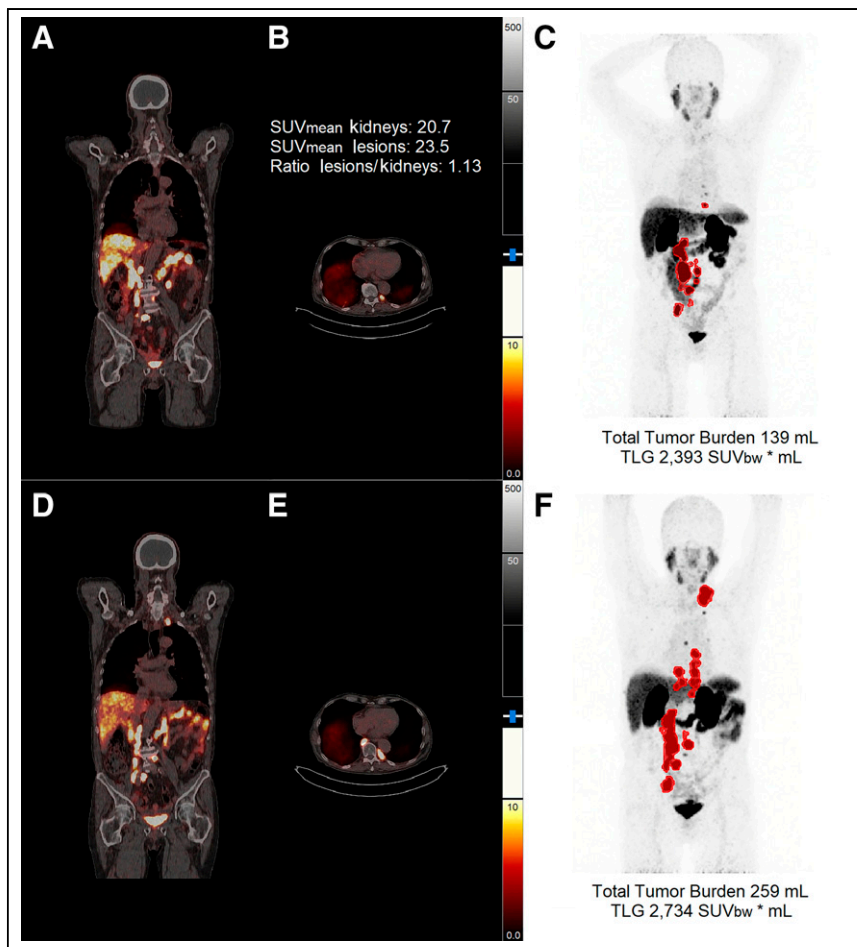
Results from one nonresponder. (A–C) PET/CT imaging before first therapy cycle. (D–F) PET/CT imaging after 2 therapy cycles. (C and F) Maximum-intensity projections together with TTB and TLG. Lesions with SUV < 3.5 were not included. SUV_{bw} = standardized uptake value based on body weight.
